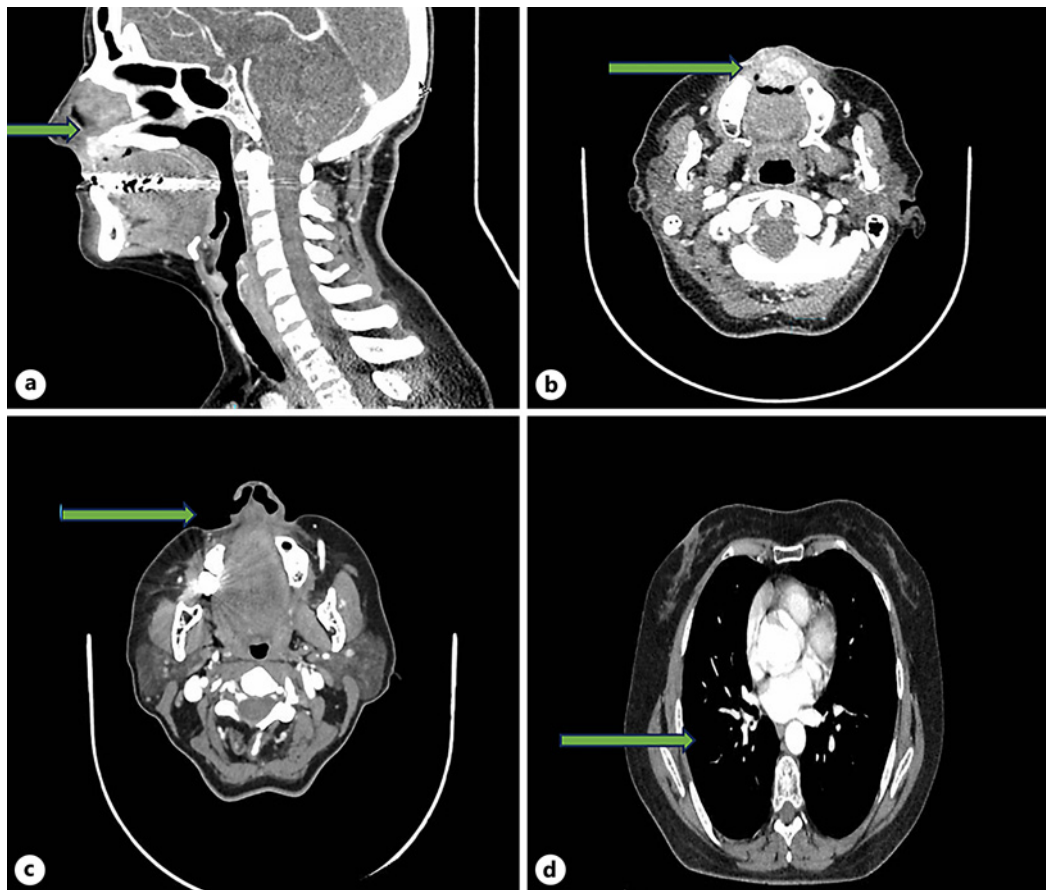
Images of the evolution of target lesion response during treatment. a, b Focal nodular lesion measuring 12×13 mm with contrast hyperenhancement, partially occupying the upper vestibule, well defined, slightly heterogeneous. c, d CT scan after 5 months of treatment with alectinib in pathological complete response according to RECIST 1.1 criteria.
